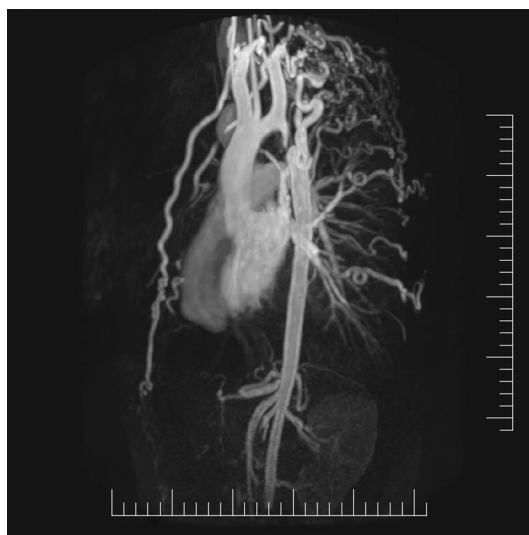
Magnetic resonance imaging demonstrating extensive collaterals in patient with unrepaired coarctation of aorta.
